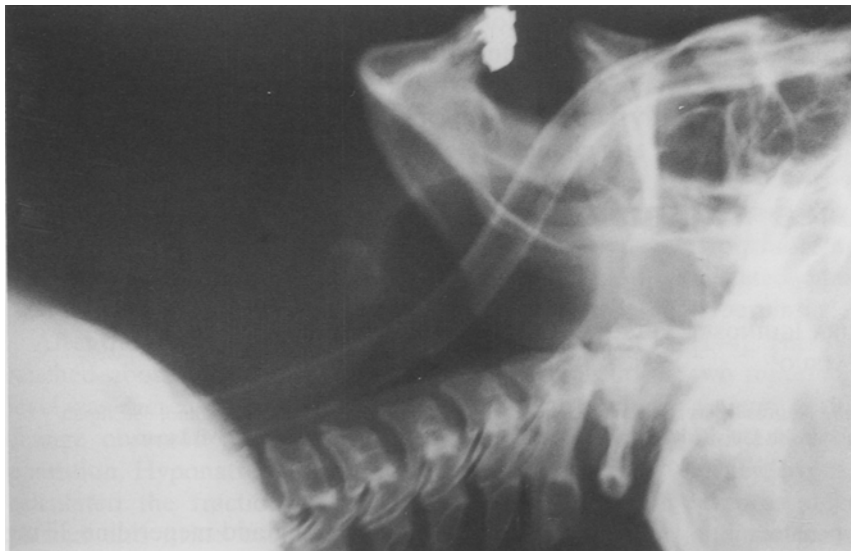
Lateral roentgenogram of the oropharyngeal balloon that anchors the ETC behind the hard palate and inhibits accidental removal. (Picture is not from this case)
